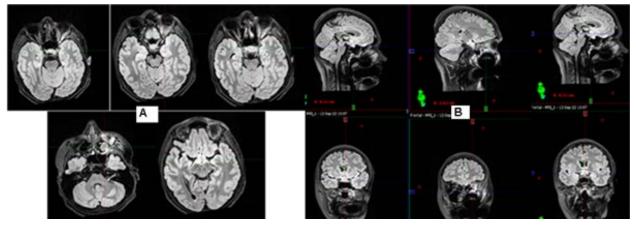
A) Axial MRI and B) Sagittal and frontal MRI-The lumpy mass cranially compresses the hypothalamus, involves the right optic tract to a greater extent than the left, forming a cystic area in the left optic tract. It generally extends from the anterior commissure to the mammary bodies without involving any of these structures, but the supra-optic recess is almost annihilated by the mass. In the diffuse analysis, it has signs of hypercellularity, and after contrast with an intravenous bolus, it moderately and slightly inhomogeneously shortens its T1 relaxation.
